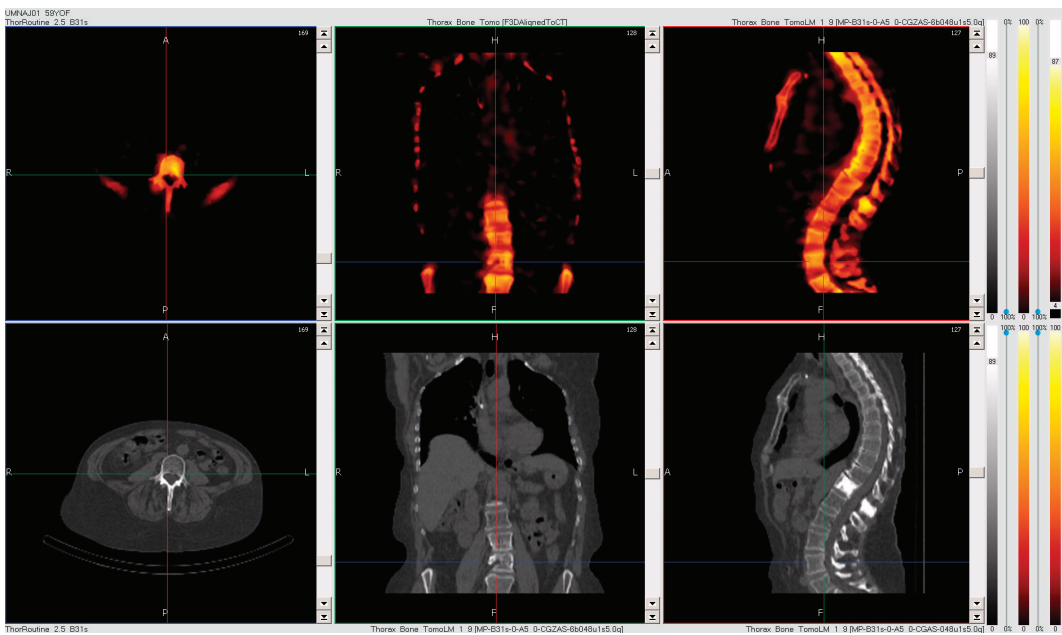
Top row: Context based reconstruction xSPECT Bone. Bottom row: CT image. (display from research workstation)
